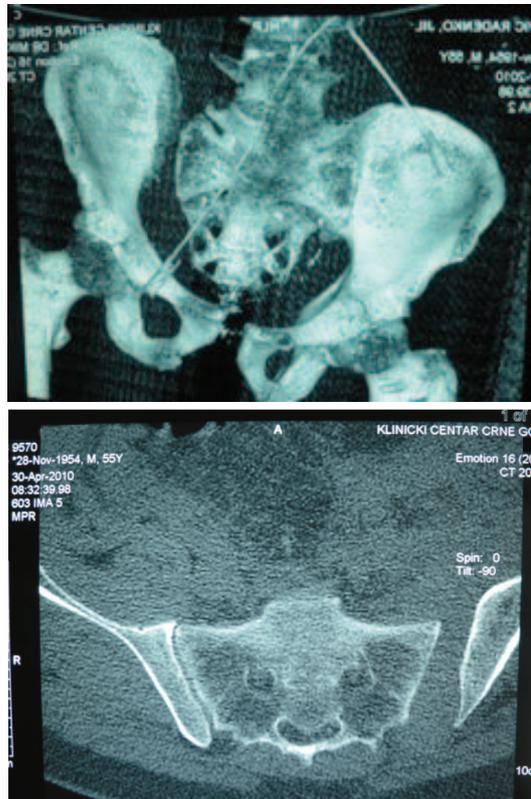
Vertical and rotational instability of the pelvic ring [computed tomography (CT)].
